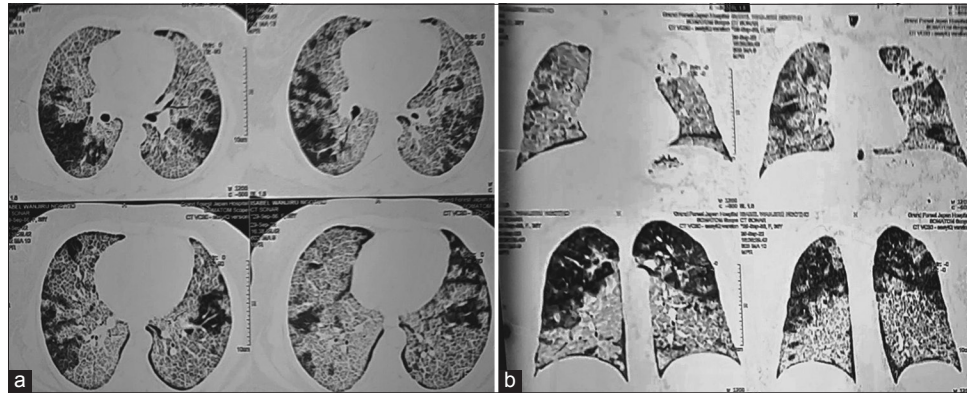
A 36-year-old lady with pulmonary alveolar proteinosis who presented with progressive dyspnea and cough. A cropped grayscale lung window high-resolution computed tomography of the chest demonstrates a “crazy paving” pattern as; (a) Extensive diffuse bilateral thickening of the lung interstitium with superimposed interlobular septal thickening in the axial view. (b) Bilateral diffuse, symmetrical ground-glass attenuation in the coronal view.
